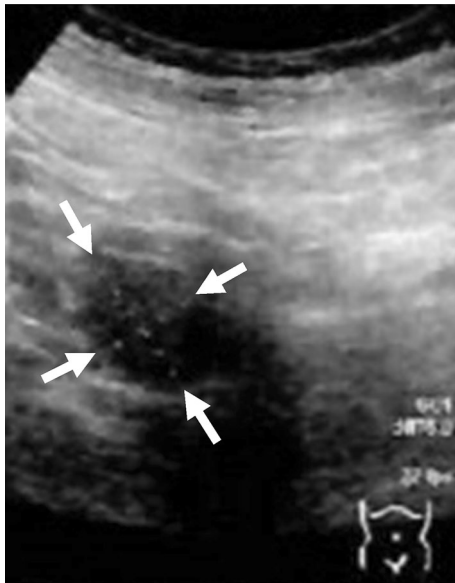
A transabdominal ultrasound image showing the right elliptic-shaped ovary (arrows) in a 34-year-old woman with right adnexal tenderness. She was diagnosed with adnexitis by a gynecologist
